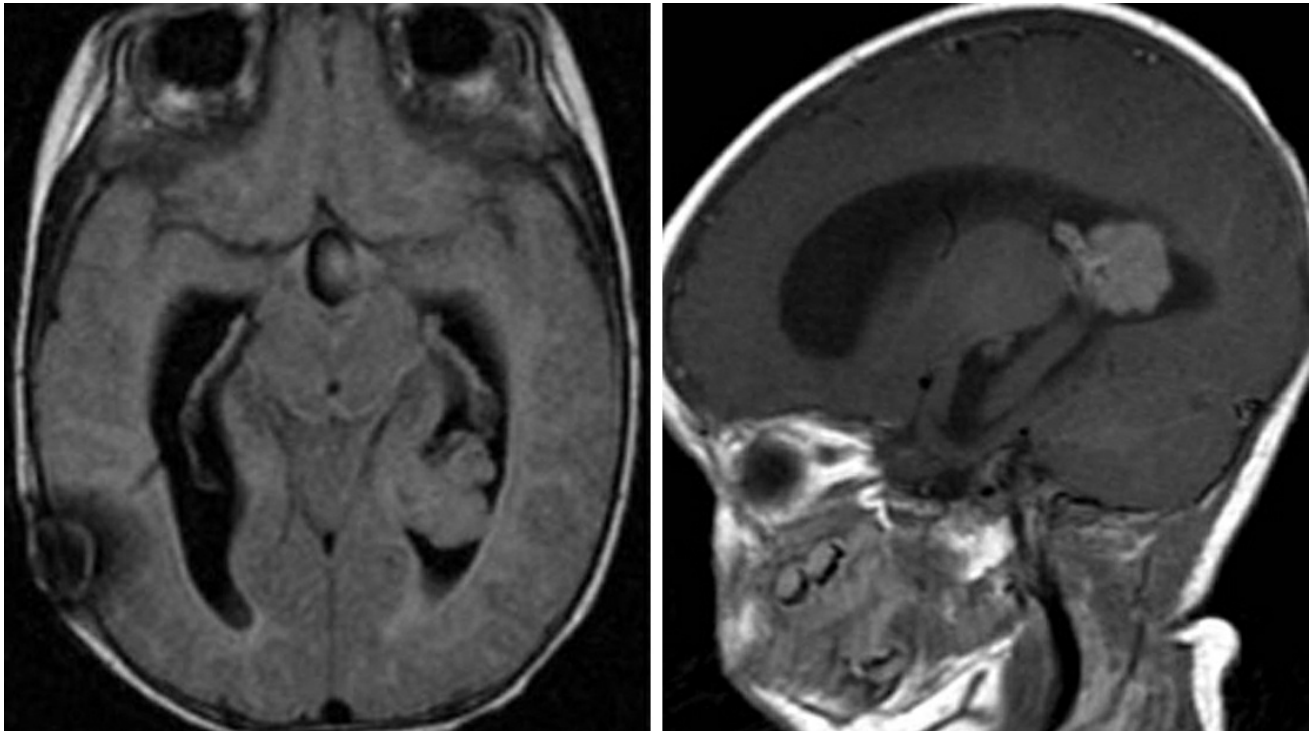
Axial FLAIR (left) and sagittal T1WI postcontrast (right) demonstrate a lobulated intraventricular enhancing tumor. This choroid plexus carcinoma is indistinguishable from [choroid plexus papilloma](#) given its lack of invasive features.
